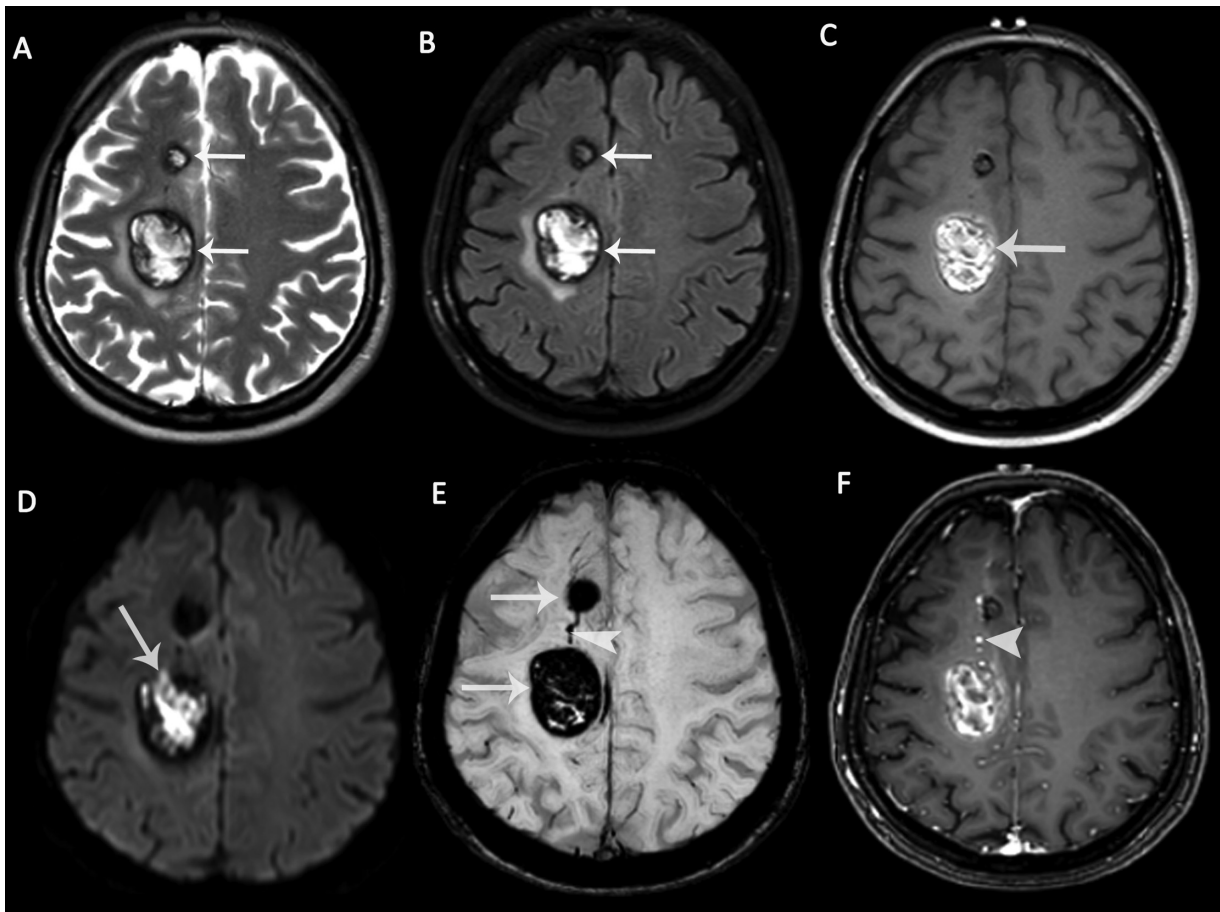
Magnetic resonance imaging (MRI) of a 40-year-old female patient with multiple cavernous malformations (CMs). Axial (A) T2-weighted image (T2WI) and (B) fluid attenuated inversion recovery (FLAIR) image demonstrate two CMs adjacent to each other, showing typical peripheral hemosiderin rim (arrows) with heterogeneous internal signals. There is perilesional edema around the larger one. (C) The larger one is heterogeneously hyperintense on nonenhanced T1-weighted image (T1WI) due to intralésional subacute hemorrhage (arrow). (D) Diffusion-weighted imaging (DWI) shows hyperintense signals within the larger CM due to diffusion restriction (arrow). (E) The CMs are markedly hypointense on susceptibility-weighted imaging (SWI) due to “blooming artifacts” (arrows). There is a developmental venous anomaly (DVA) between the two cavernomas (arrowhead). (F) Enhancement is not seen in CMs on the contrast-enhanced T1WI, while DVA shows enhancement (arrowhead).
